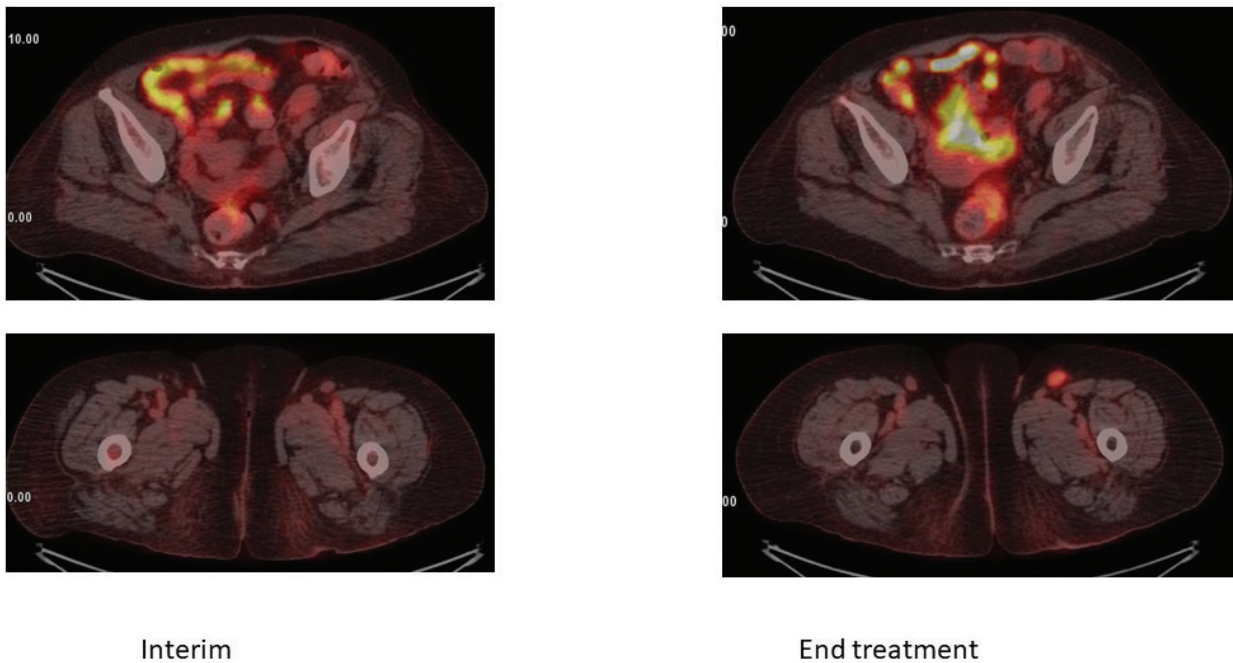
Interim evaluation -Low-grade uptake of left external iliac lymph node block of size 4,5X2,8cm (SUVmax=3,1). End treatment evaluation-Low-grade uptake of left external iliac lymph node block of reduced size 3,5X1,8cm (SUVmax=2,95). Left inguinal lymph node increased size (diameter 2,3cm instead of 1,3) with high-grade uptake (SUVmax=6,3).
